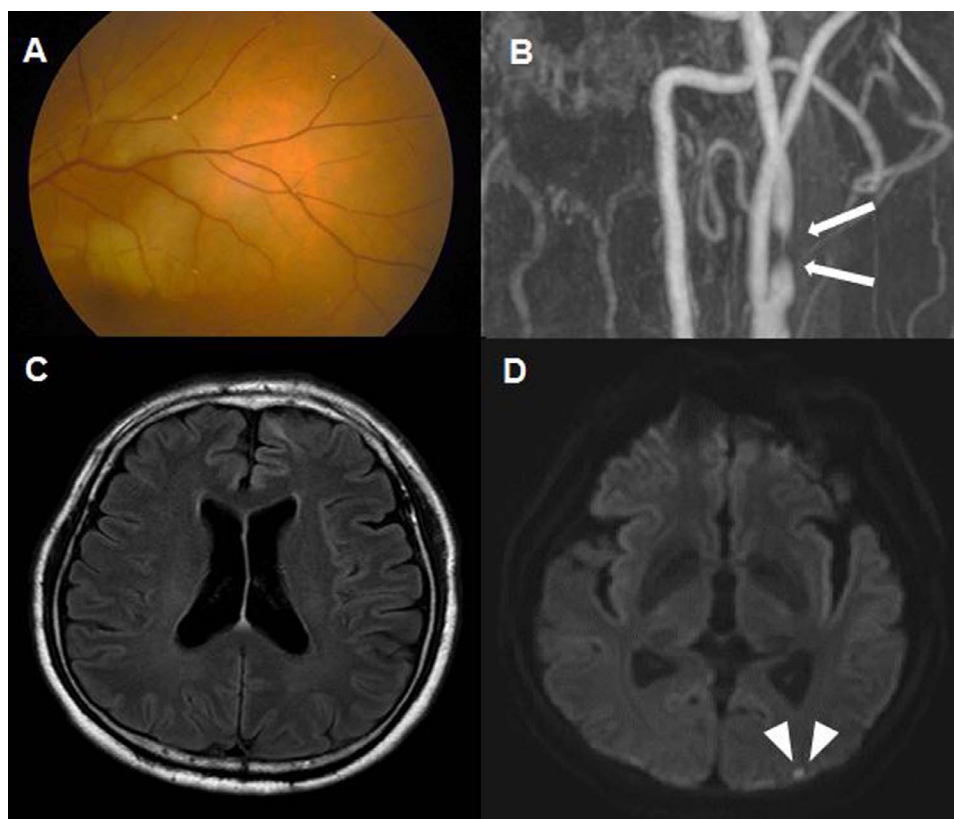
(A) A case of branch retinal artery occlusion (BRAO) with multiple visible emboli observed in a branch of the superotemporal retinal artery in a 77-year-old man. (B) Severe stenosis by NASCET criteria at the left proximal internal carotid artery, regarded as the cause of retinal emboli, is shown in the MRA (white arrow). (C) White matter hyperintensities, cerebral microbleeds, or silent lacunar infarct is not visible in brain MRI (FLAIR image), but (D) a concurrent acute infarction in left occipital lobe is shown in a T2-weighted MRI. MRA, magnetic resonance angiography; MRI, magnetic resonance image; FLAIR, fluid-attenuated inversion recovery.
